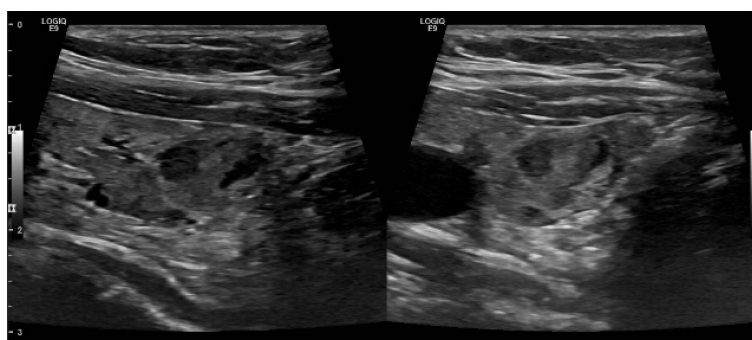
Ultrasound image of a mixed-composition, isoechoic nodule within the lower anterior aspect of the right thyroid lobe (TI-RADS 2), later confirmed to represent an intrathyroidal parathyroid adenoma
